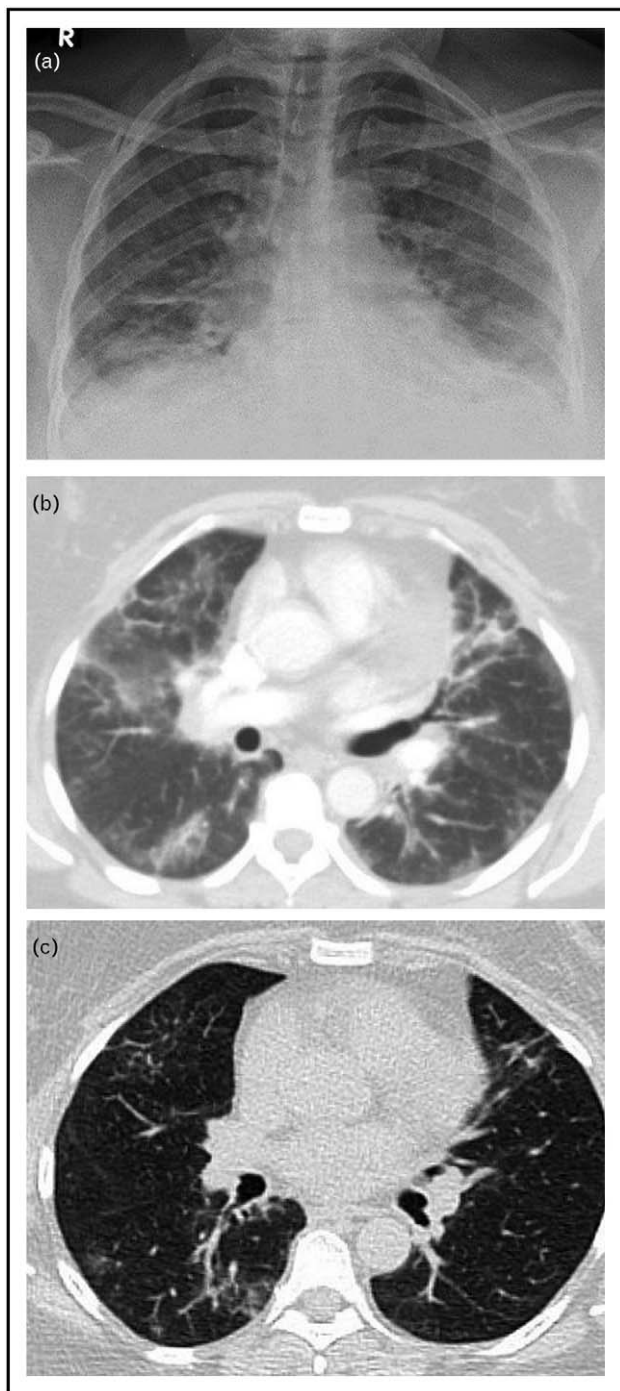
Radiologic exams of patient A. (a) Chest radiograph on admission showing bilateral consolidations in the middle and lower zones. (b) Chest computed tomography before therapy showing a reticular pattern, ground glass and consolidations. (c) Chest HRCT after steroid therapy with regression of consolidations.
